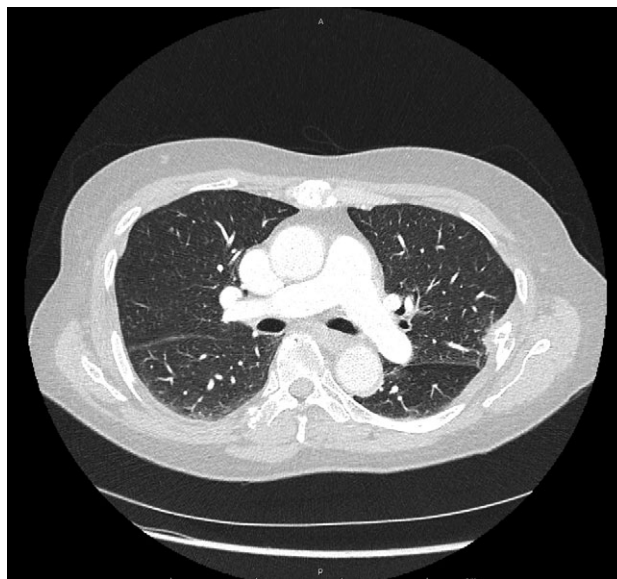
CT pulmonary angiogram performed in February 2016 revealed near-complete resolution of pulmonary nodules, pleural thickening and pleural effusion.
